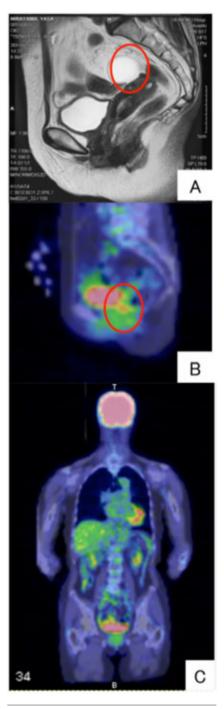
Imaging findings. A) MRI detected a tumor in the vaginal wall (circled). B) PET-CT. Positive accumulation of FDG was recognized in the site where MRI had detected the tumor (circled). C) No abnormal accumulation was recognized in any organ including the lung fields other than the vaginal wall.
